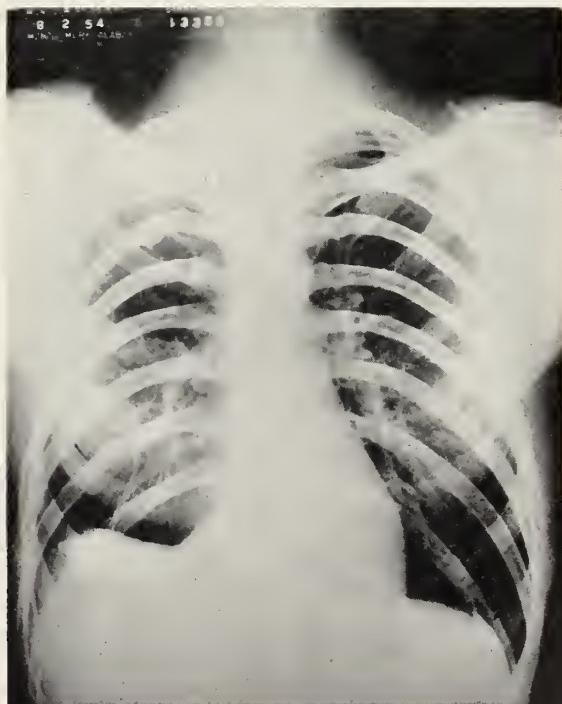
Chest roentgenogram of the patient in case report I, taken 22 months following right upper lobectomy, showing no evidence of recurrence of histoplasmosis.
